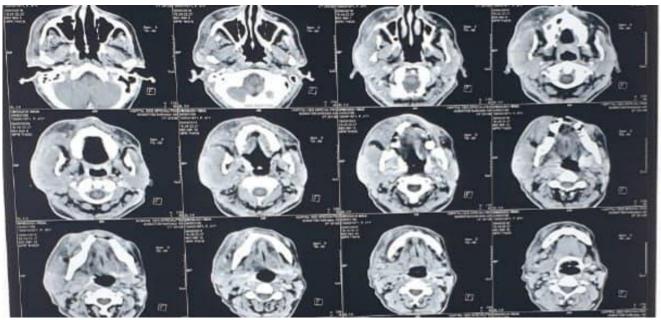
cervical axial CT scan showing the increase in the size of the parotid
